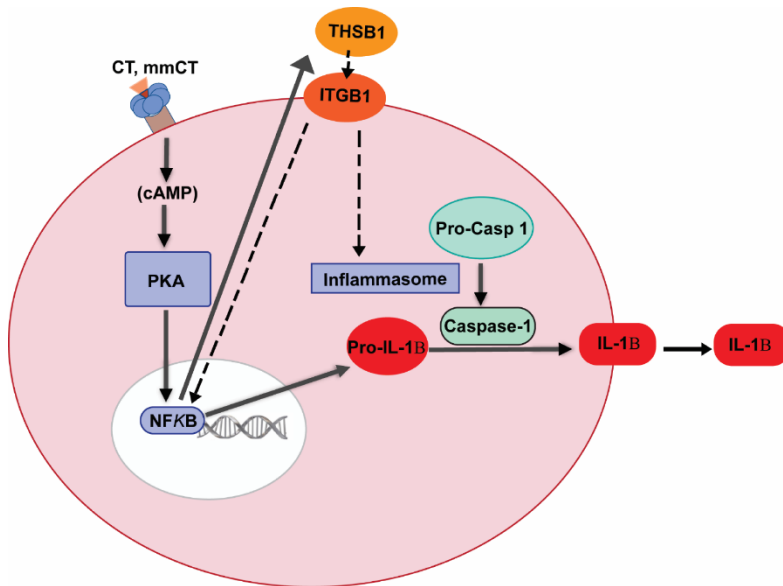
Mechanism of adjuvant action of CT and mmCT
